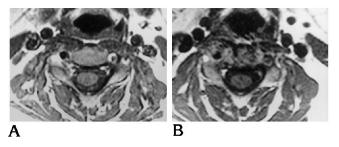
T1-weighted axial spin-echo MR images at the level of C3-4, originating from two multisection stacks acquired with a saturation pulse placed inferiorly.
